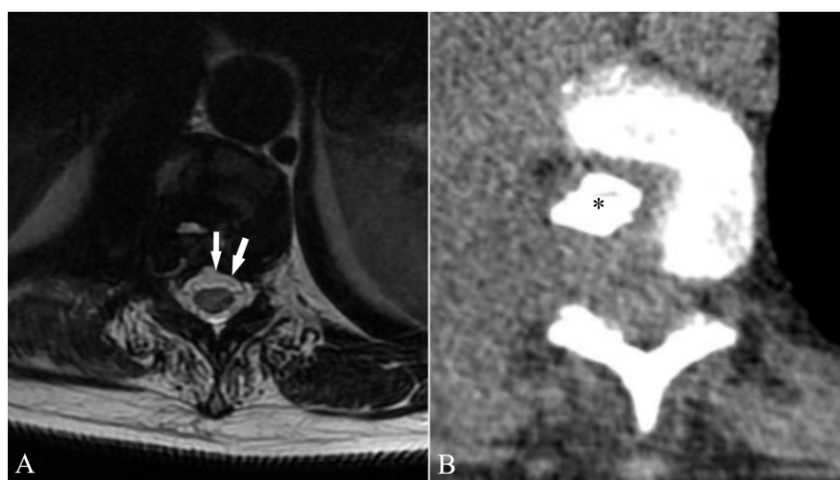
(A) Postoperative axial T2 weighted magnetic resonance imaging demonstrates complete decompression of the medulla (arrows) at the T10–T11 intervertebral level; (B) correct placement of the autogenous rib graft (asterisk) was confirmed on computerized tomography axial image at the same intervertebral level.
